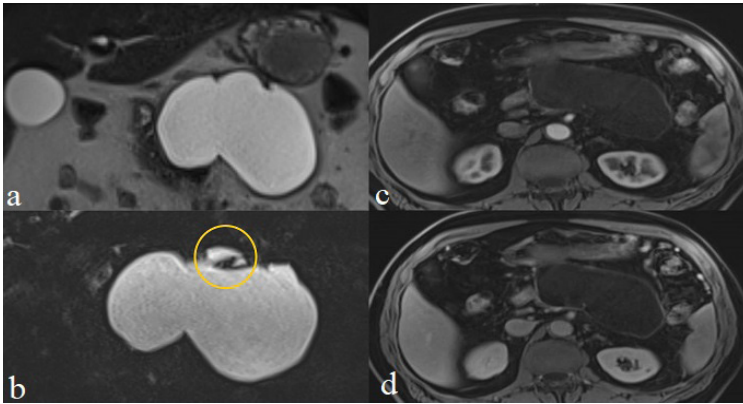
A female patient, age 54, with a pseudocyst. The pseudocysts of the pancreas have a thin, smooth wall, homogeneous liquid intensity on T2WI, and no solid particles in the fluid (a). On MRCP, the cystic lesion is shown to communicate with the pancreatic duct. No noticeable contrast enhancement is detected on MRI scans (c, d).
